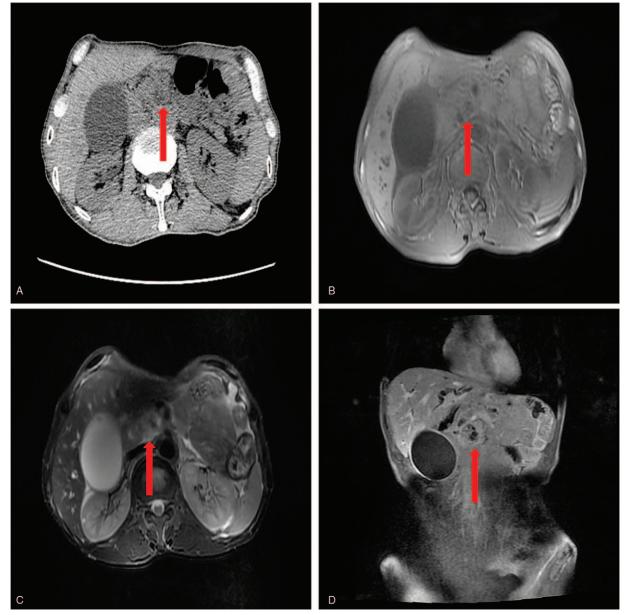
Chest-abdomen CT and MRI. (A) CT showed a soft tissue mass with multiple irregularly shaped, low-density shadows (arrow) in the uncinate region of the pancreas. MRI of the pancreatic mass showed an equal signal for T1 (B, arrow), and a slightly longer signal for T2 (C, arrow). (D) Enhanced MRI showed multiple nonenhanced areas in the pancreatic mass (arrow). CT = computed tomography, MRI = magnetic resonance imaging.
